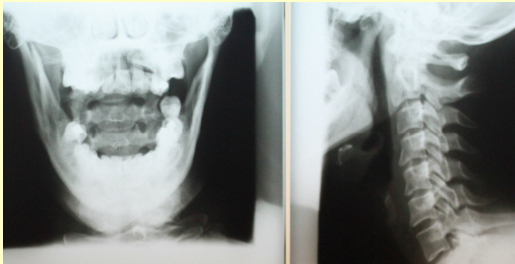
X-Ray of a patient with cervicogenic dizziness with a rotated Cx1 and loss of lower cervical lordosis
